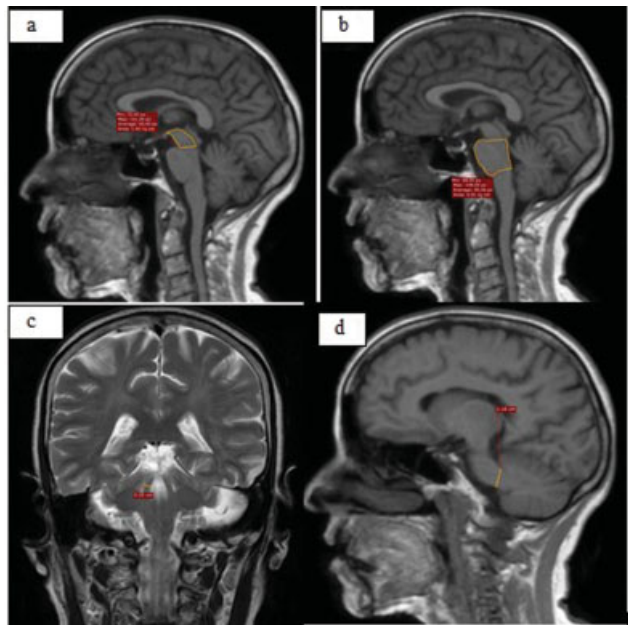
MRI T1W sagittal image in a control patient showing the midbrain area (1.42 cm^2) (a), the area of pons (4.91 cm^2) (b), T2W coronal image showing the width of superior cerebellar peduncle (0.33 cm) (c), and sagittal image shows the middle cerebellar peduncle width (1.16 cm) (d).
